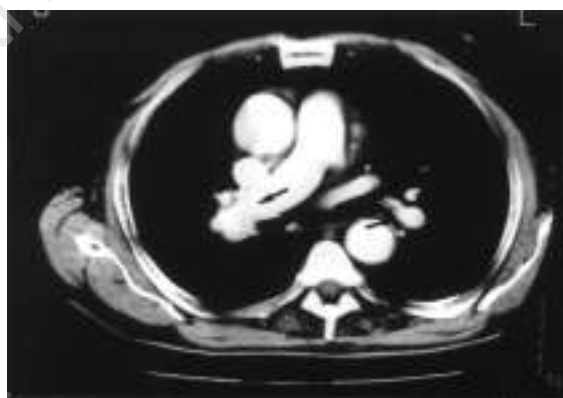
CT showing better filling of the right pulmonary artery and complete resolution of the thrombus in the left pulmonary artery.
